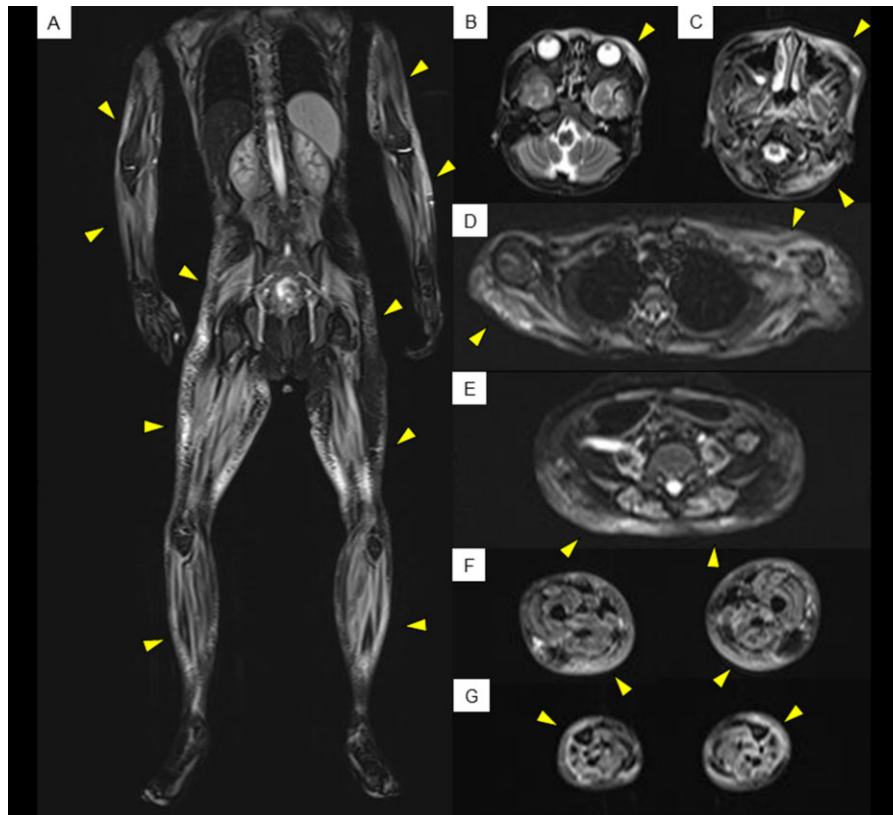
Whole-body MRI. Whole-body MRI on short T1 inversion recovery imaging shows generalized high-intensity signals in the generalized muscle and s.c. lesions (yellow arrow) suggestive of myositis and s.c. oedema. A, coronal view of the whole body. B and C, axial views of the head. D, axial view of the shoulder. E, axial view of the body trunk. F, axial view of the thigh. G, axial view of the lower leg
